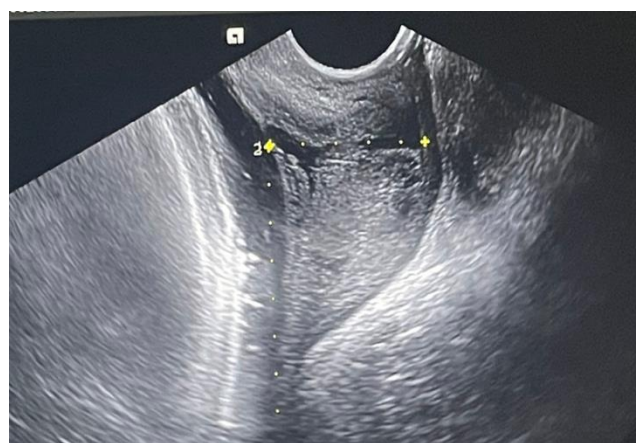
Transvaginal ultrasound scan of cervix showing PCA of 100 degrees
